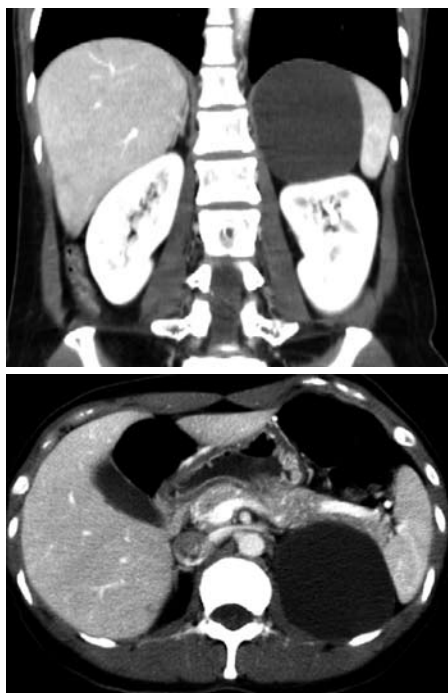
An abdominal computed tomography scan showing a 9 cm well-defined cystic lesion, which abuts the spleen, kidney and pancreas tail.
